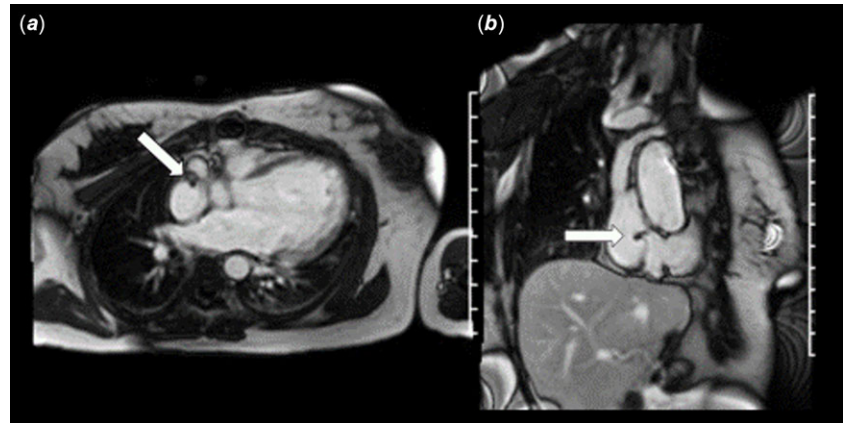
Cardiac MRI of Fontan thrombus. Single-shot delayed-enhancement images (TI = 600 msec) of patient with Fontan thrombus. White arrow indicates area of absence of contrast uptake, in this case, thrombus.
